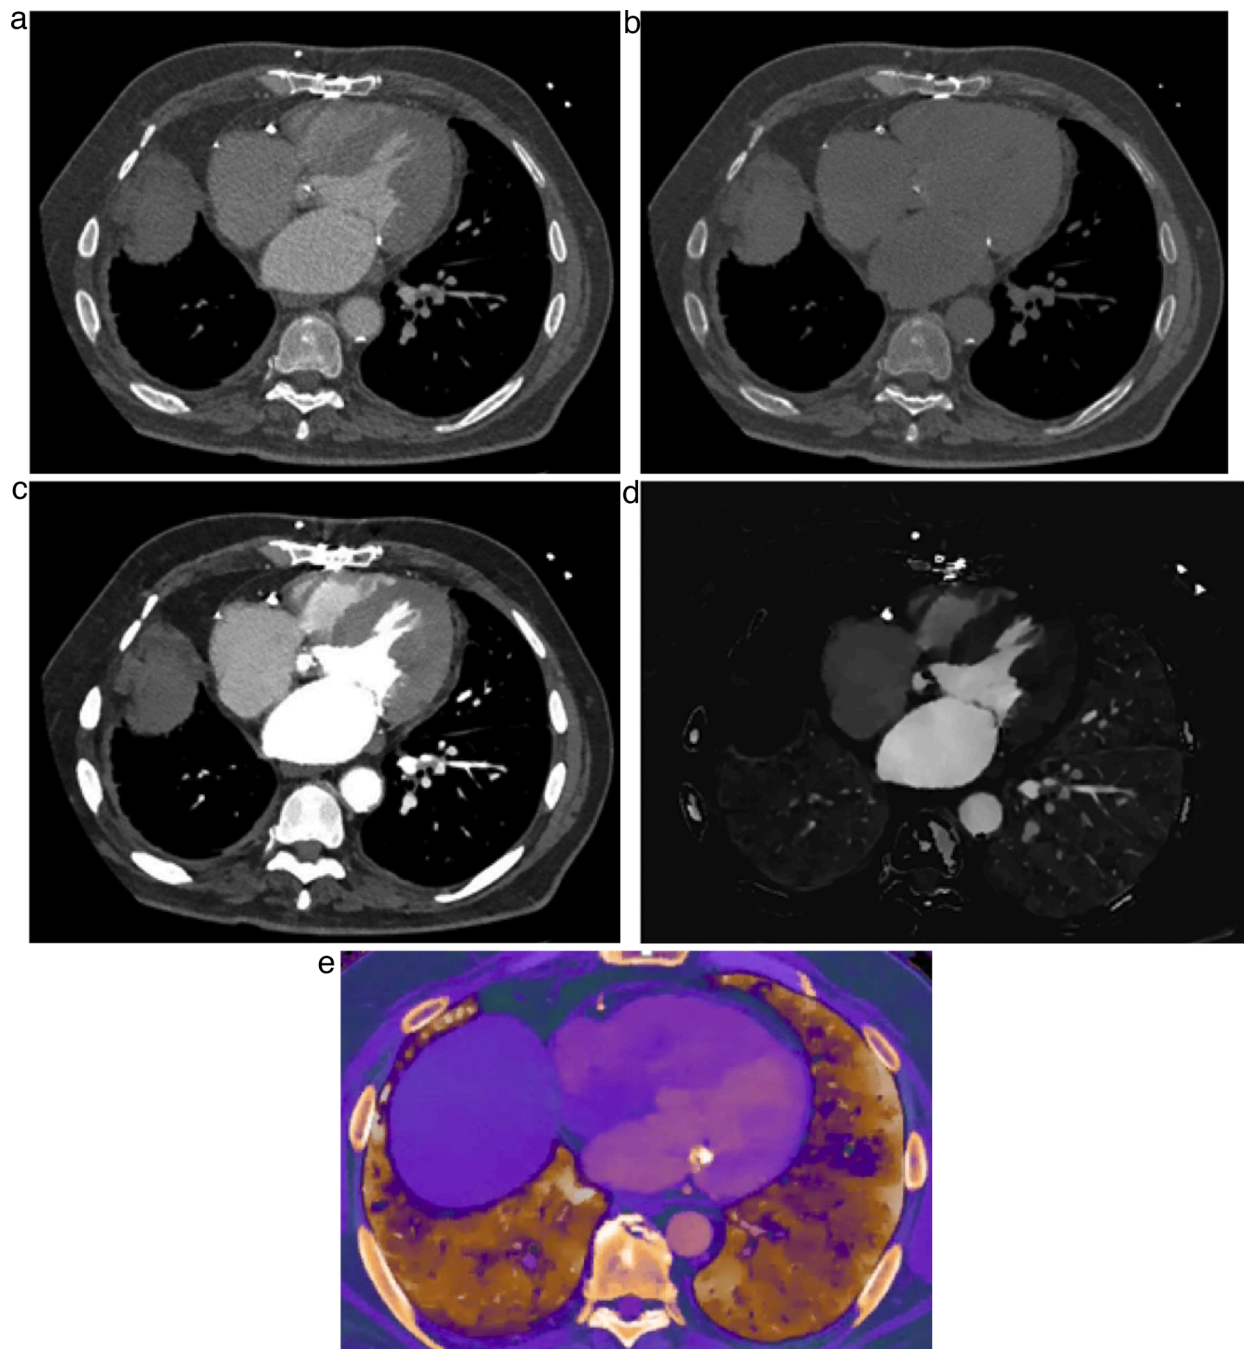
Most useful DECT reconstructions for routine clinical cardiovascular applications. (a) Conventional CT image, similar to routine CT image, providing a starting point for assessment (b) Virtual non contrast image, obtained by removal of iodine from contrast enhanced image, can serve as a surrogate for true non contrast image (c) Low keV images, provide contrast boost because of increased attenuation, resulting in better depiction of contrast enhancement (d) Iodine density image, demonstrates the distribution of iodinated contrast and can be used for lesion characterization and organ perfusion and allows for quantification of enhancement, (e) Overlay image, combines anatomical information of CT with iodine distribution; can be used instead of iodine density images.
